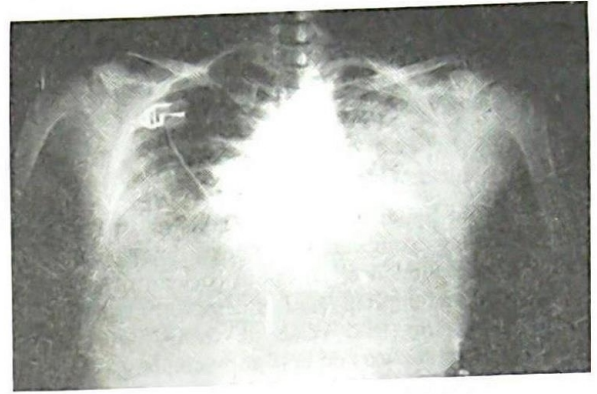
Chest x-ray during second admission
